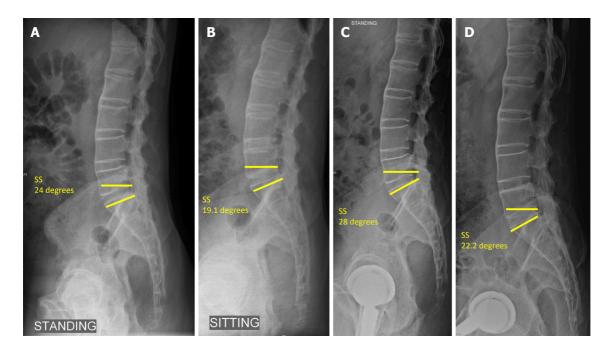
Lateral lumbosacral spine radiographs. A: Pre op standing; B: Sitting compared to; C: Post op standing; D: Sitting showing the change in sacral slope < 10 degrees with reduced sacral slope indicating posterior pelvic tilt and stuck sitting pattern in ankylosing spondylitis (sacral slope < 30 degrees on sitting and standing typical of stuck sitting pattern). SS: Sacral slope.
